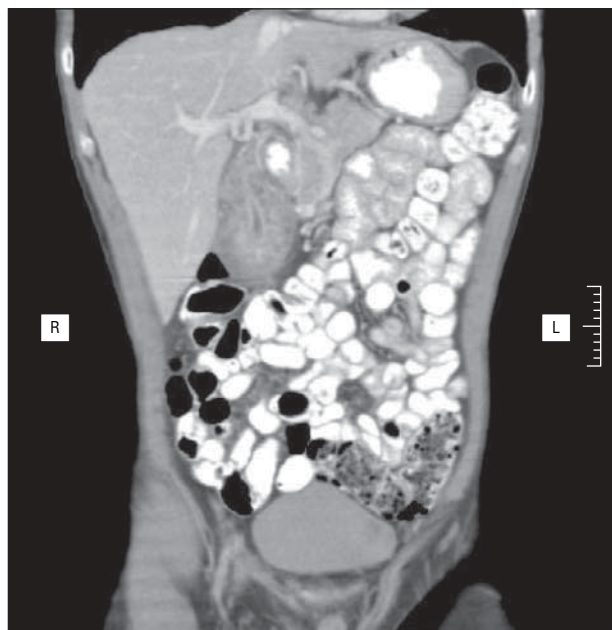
Computed tomographic scan of the abdomen shows a markedly thickened and heterogenous gallbladder with an enhancing gallbladder wall and very narrowed lumen.
